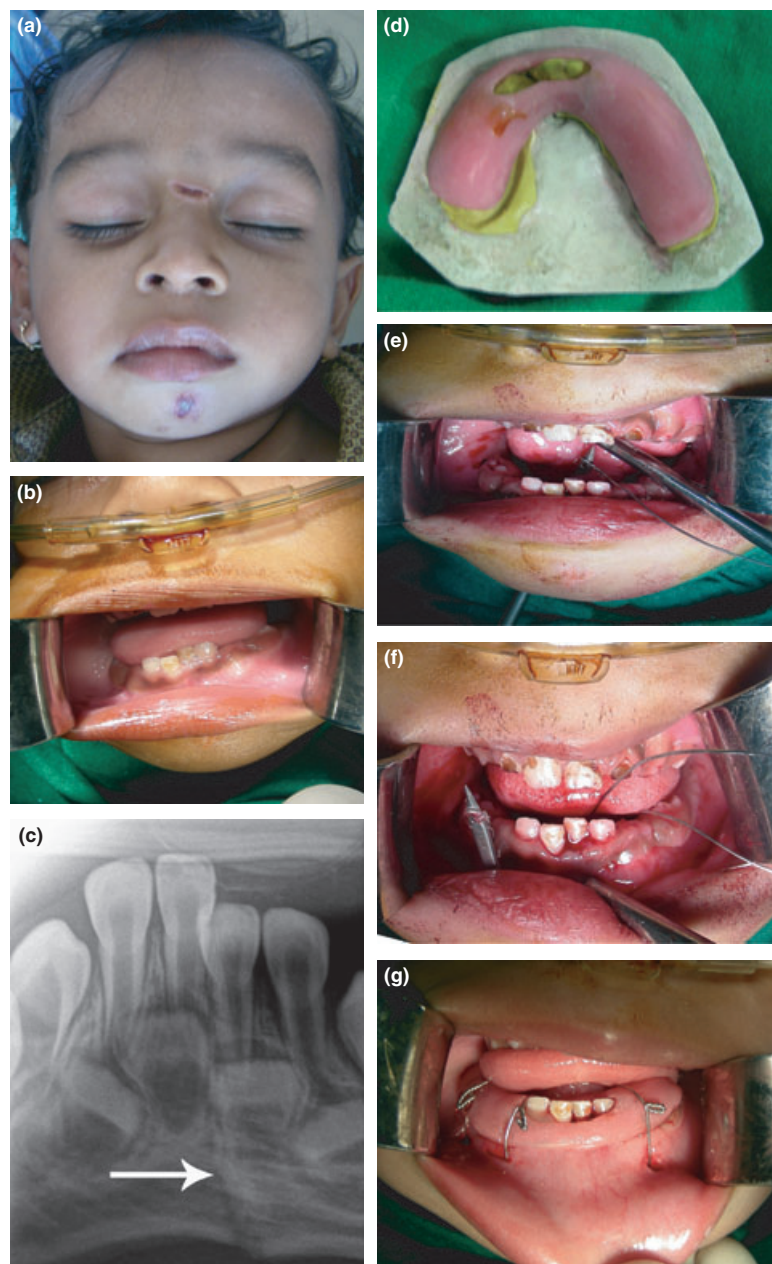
(a) Profile photograph showing abrasions over chin and nose. (b) Intraoral photograph showing deranged occlusion. (c) Intraoral periapical radiograph reveals symphysis fracture. (d) Open cap splint prepared on cast in reduced position. (e) Awl on lingual side fed with 26 gauge wire. (f) Awl in buccal vestibule. (g) Open cap splint *in situ*.
